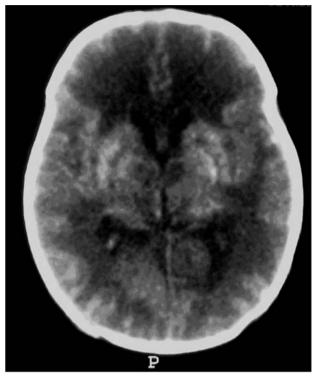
Unenhanced CT showing large areas of the white matter hypodensity and bilateral basal ganglia hemorrhage.
